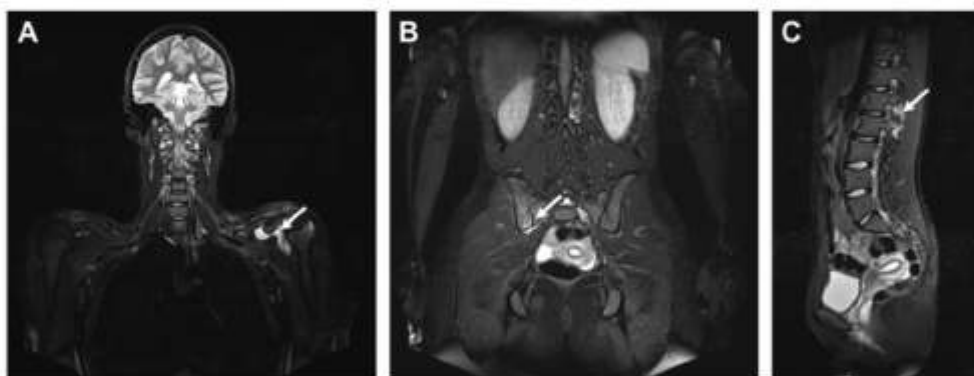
Whole body MRI in a 17-year-old girl with juvenile idiopathic arthritis (JIA) enthesitis-related arthritis (ERA) subtype, HLA-B27 positive. T2 TIRM images in coronal (A and B) and sagittal (C) planes show synovitis in the left shoulder with some bone marrow edema in the proximal metaphysis of the humerus (A), right-sided sacroiliitis (B) and L1/2 left intervertebral joint synovitis with some bone marrow and soft tissue swelling of surrounding tissues.
